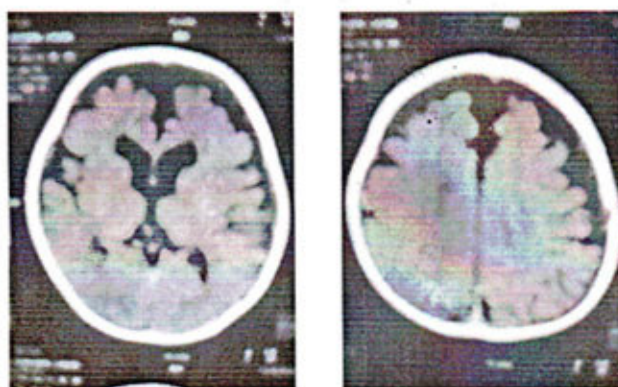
Post-operative CT scan of brain
